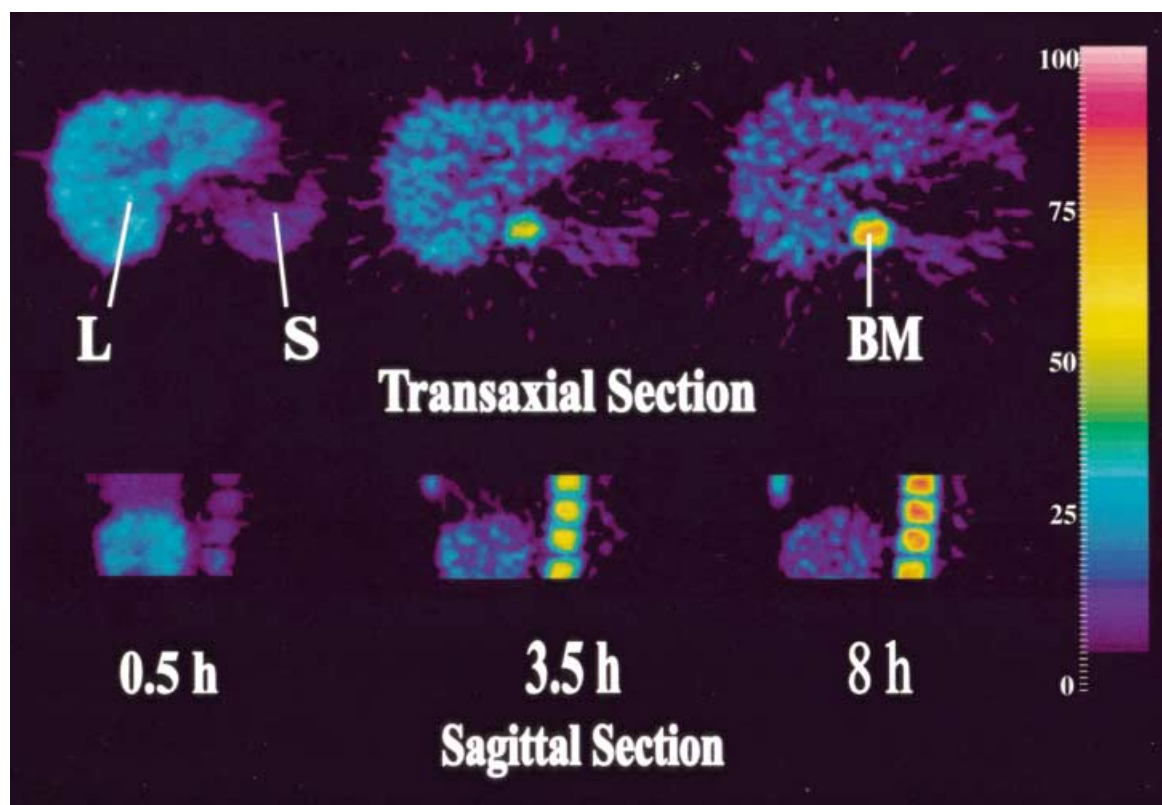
Uptake values of labelled ^{52}Fe -polymaltose in the liver (L), spleen (S) and bone marrow (BM) in one of the patients taken at 0.5, 3.5 and 8 h after injection. The injected radioactivity (Bq) is assumed to be homogeneously distributed all over the body. With the assumption of a tissue density of 1 g/cc, standardized uptake values (SUV) therefore indicate tissue uptake per cc in relation to the injected radioactivity when normalized for the average body uptake per cc. In this patient, maximum radioactivity concentration in BM after 8 h is up to 103 times higher than average body concentration.
